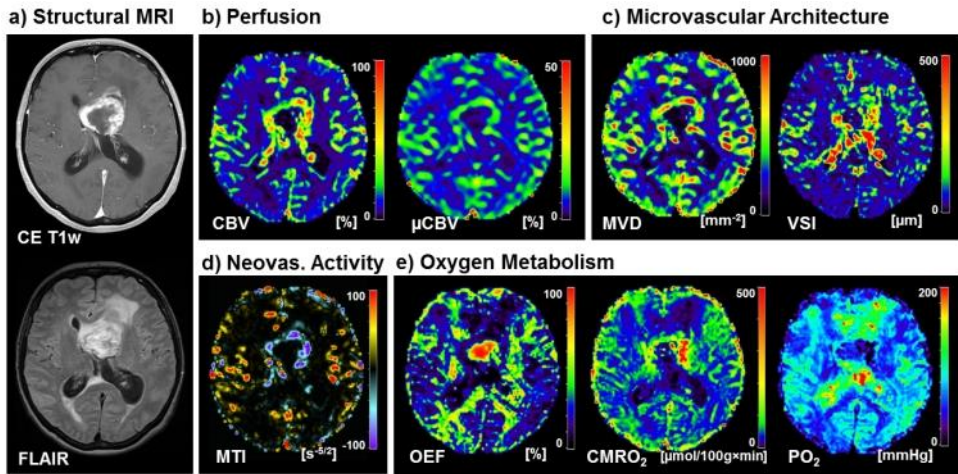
Physiological MR imaging of a patient diagnosed with glioblastoma.
